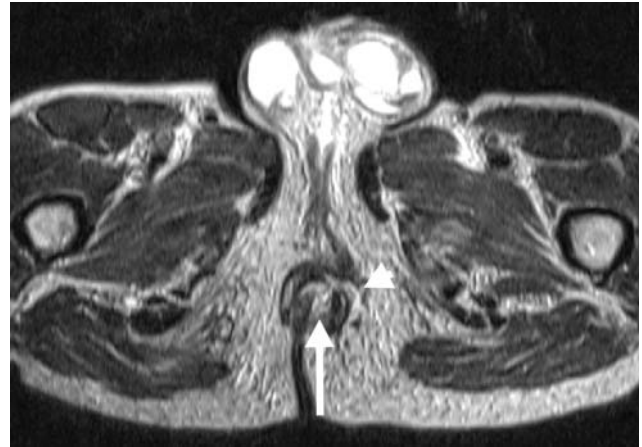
The same patient as presented in the Fig. 32. Axial T2-weighted MR image shows a transsphincteric fistula (arrowhead) with a clearly visible internal opening (arrow).
